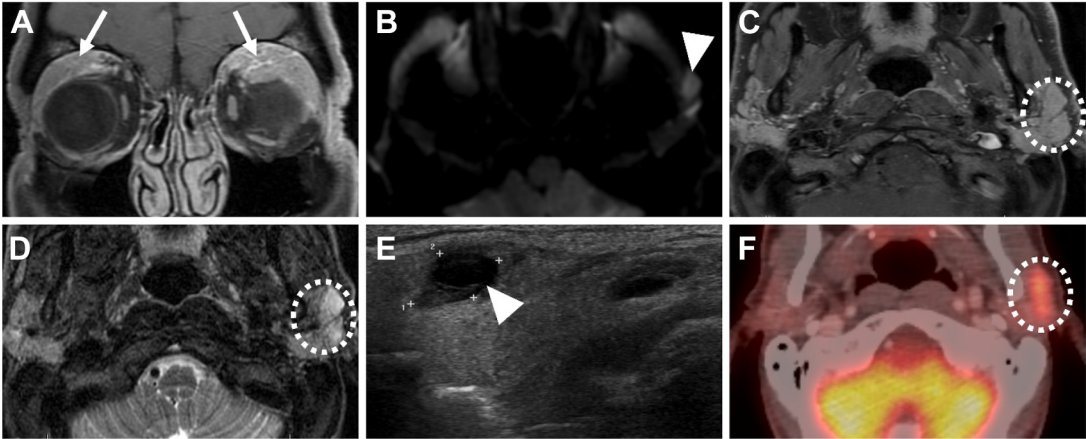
Patient with orbital lymphoma. (A) coronal postcontrast T1-weighted image shows infiltrative enhancing tissue in bilateral superior-lateral extraconal orbits (arrows), in keeping with lymphoma. (B) High b-value DWI image on orbit MR additionally shows asymmetrical diffusion restricting foci in left parotid (arrowhead). Postcontrast T1-weighted image (C) and T2-weighted image (D) show subtle left superficial parotid nodules with mild T2 hyperintensities and enhancement similar degree to background parotid parenchyma (dashed circles), corresponding to diffusion abnormalities. (E) US image of left parotid shows abnormal morphology adenopathy with eccentric bulbous cystic-hypoechoic component (arrowhead). Simultaneous fine needle aspiration confirmed lymphoma involvement. (F) Subsequence FDG¹⁸ PET-CT show corresponding FDG avidity (dashed circle).
